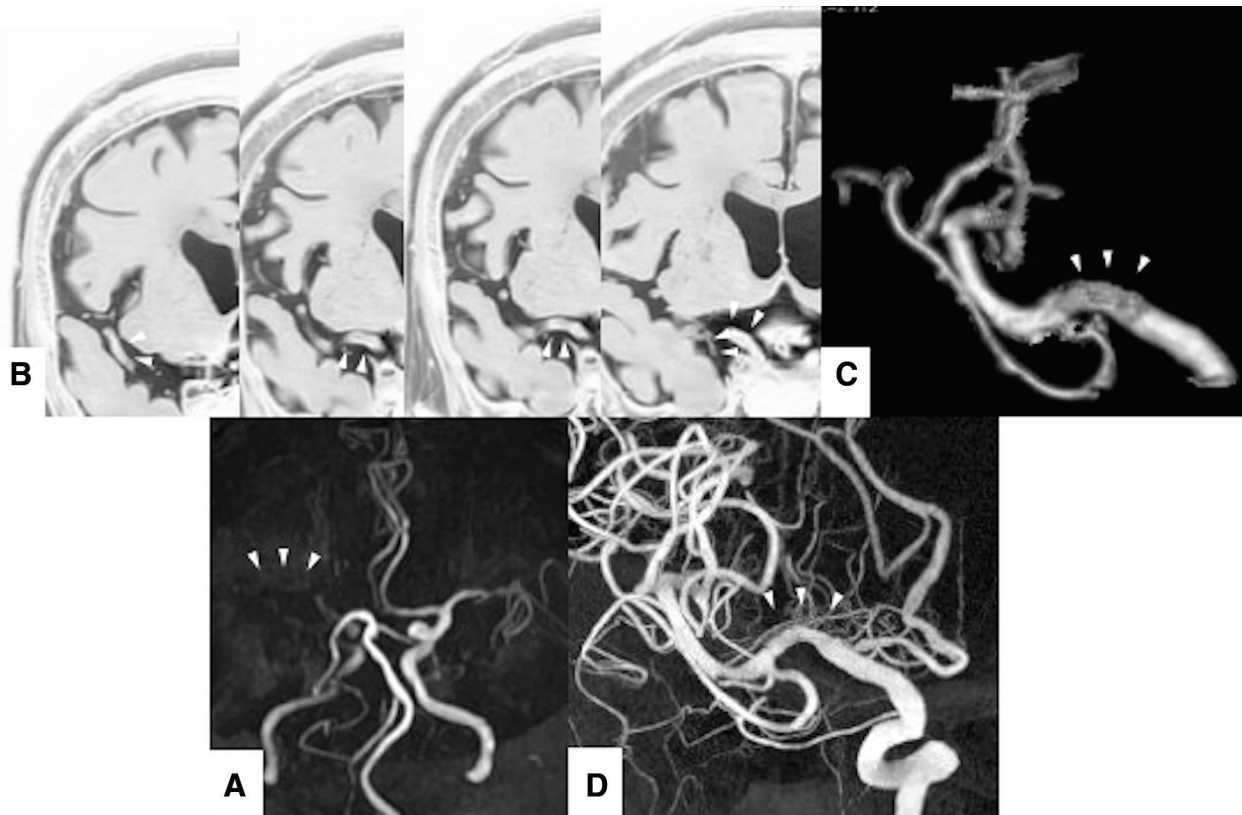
An 82-year-old woman with sudden consciousness disturbance and left hemiparesis. (A) MRA presents right MCA occlusion. (B) The occluded MCA from the proximal to the distal side of the occlusion point can be seen by MAS-MRI. The arrowheads indicate the MCA. (C) 3D image of MAS-MRI shows the occluded MCA from the proximal
